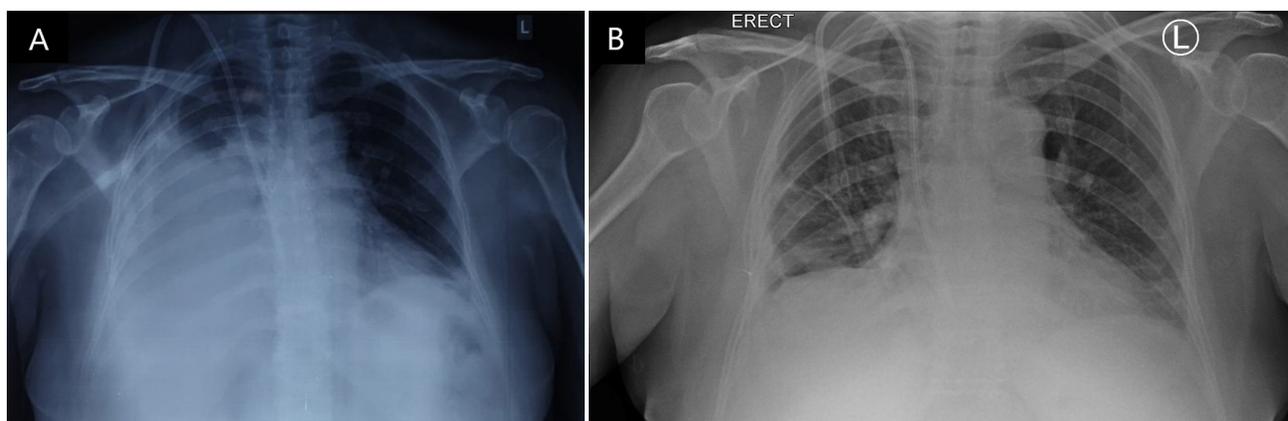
Resolution of pleural effusion as shown on chest X-ray. A) Chest X-ray on admission demonstrating massive right hydrothorax and minimal left pleural effusion, and B) follow-up chest X-ray 2 months postsurgical intervention.
